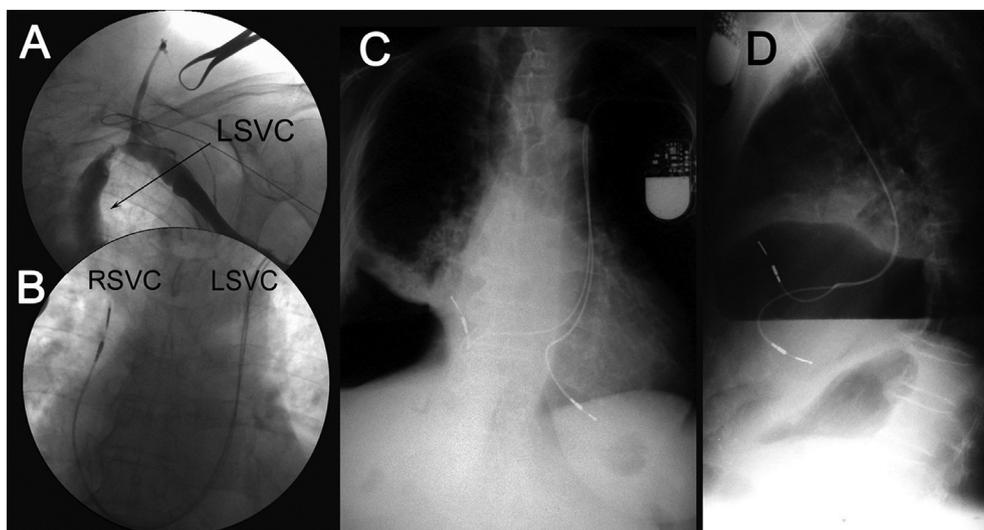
(A, B, C, D). Case 2. Intra-procedure fluoroscopy (Feb. 2006): contrast administration revealed LSV without BCV. (A) Lead manipulation showed the presence of RSV. (B) Chest X-ray from hospitalization for pneumonia (Jan. 2013). Massive opacities in the right middle lung field with parietal pleura thickening, pronounced adhesions, evidence of pneumothorax around the right lower lung field, and an air-fluid level in the right pleural cavity (C, D).
